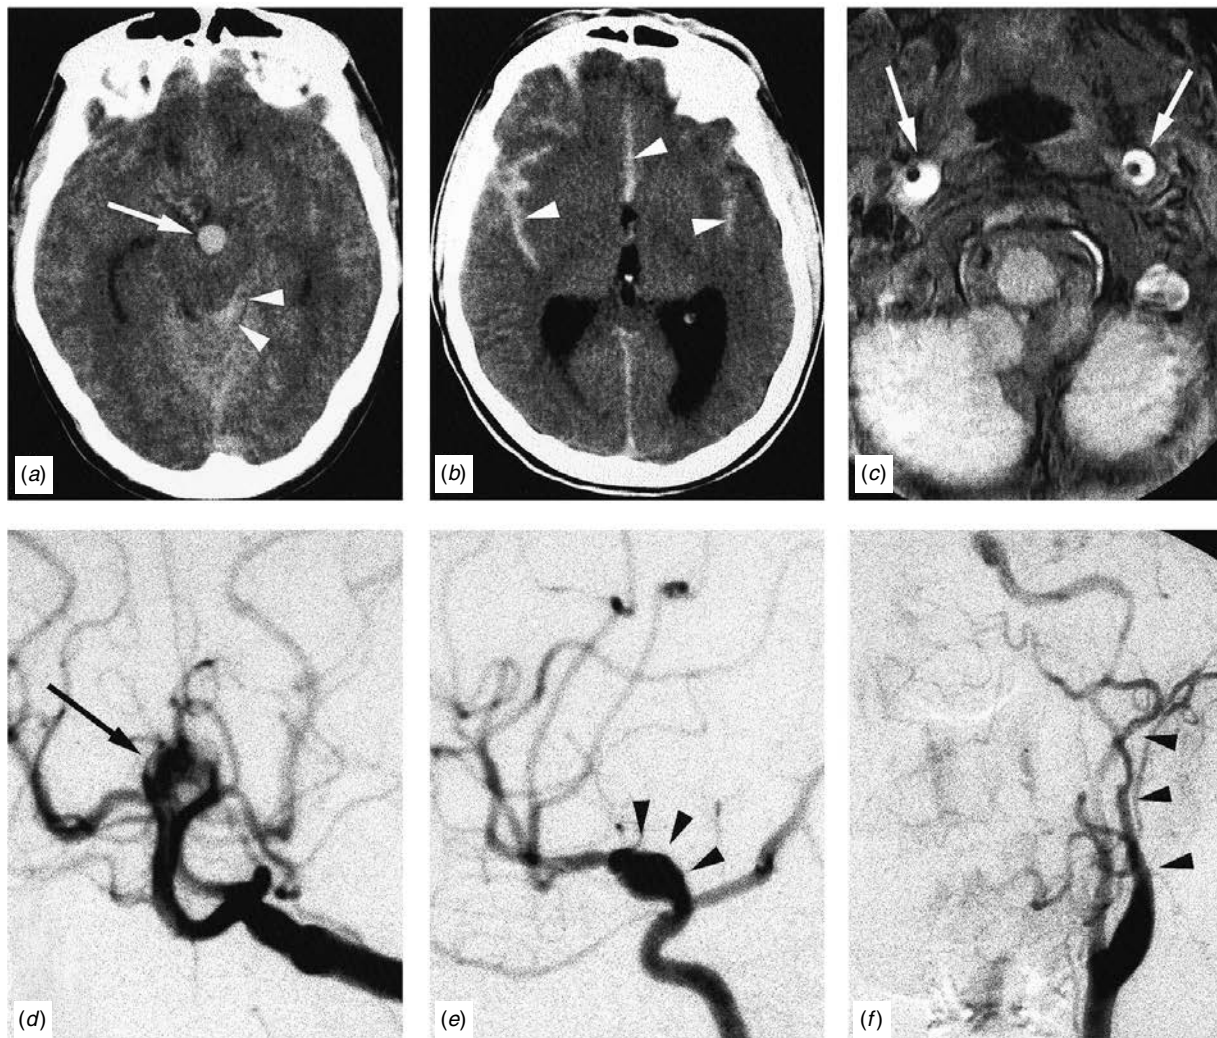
Imaging studies of aneurysms. (a) CT scan demonstrating thrombus within a basilar bifurcation saccular aneurysm (arrow) and subarachnoid blood in the left ambient cistern (arrowheads). (b) CT demonstrating diffuse subarachnoid hemorrhage from a ruptured mycotic aneurysm with blood in the Sylvian fissures and interhemispheric fissure (arrowheads). (c) Bilateral dissecting aneurysms of the cervical internal carotid arteries (arrows). In this axial MR scan, the normal hypointense flow void of each carotid artery is surrounded by the hyperintensity of fresh blood within the wall of the vessel. (d) Vertebral angiogram demonstrating a basilar bifurcation saccular aneurysm (arrow) (same case as (a)). (e) Right internal carotid angiogram demonstrating a mycotic aneurysm of the right intracranial internal carotid artery (arrowheads). There is fusiform enlargement of the artery beyond the posterior communicating artery origin to the carotid bifurcation (same case as (b)). (f) Left internal carotid angiogram revealing a carotid artery dissecting aneurysm, with irregular narrowing of the internal carotid artery beyond the common carotid bifurcation (arrowheads) (same case as (c)).
